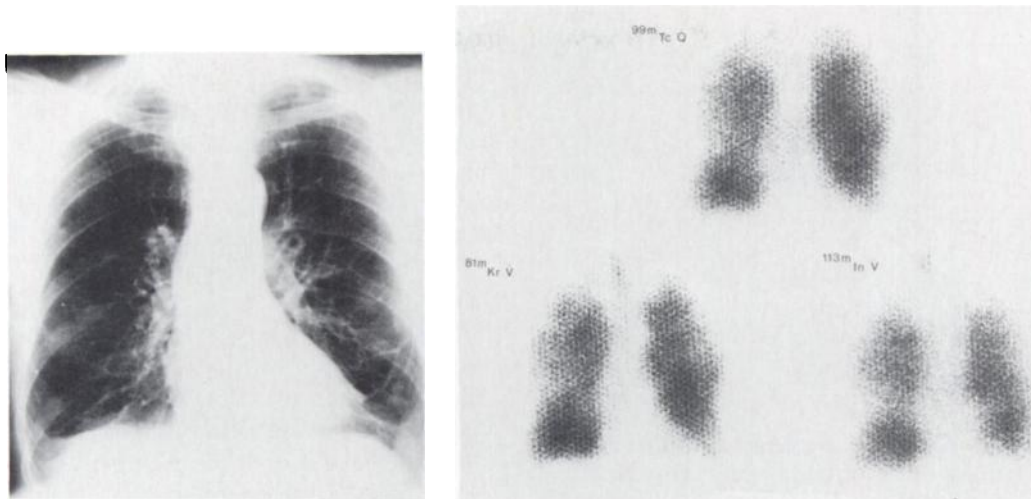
Case 2. Chronic bronchitis. Chest radiograph (left) and Tc-99m perfusion, Kr-81m ventilation, and In-113m aerosol scans in right posterior oblique views (right). Perfusion defects are matched by similar ventilation defects on both Kr-81m and In-113m scans. Note close resemblance between Kr-81m ventilation and In-113m ventilation scans and absence of central particle deposition.
